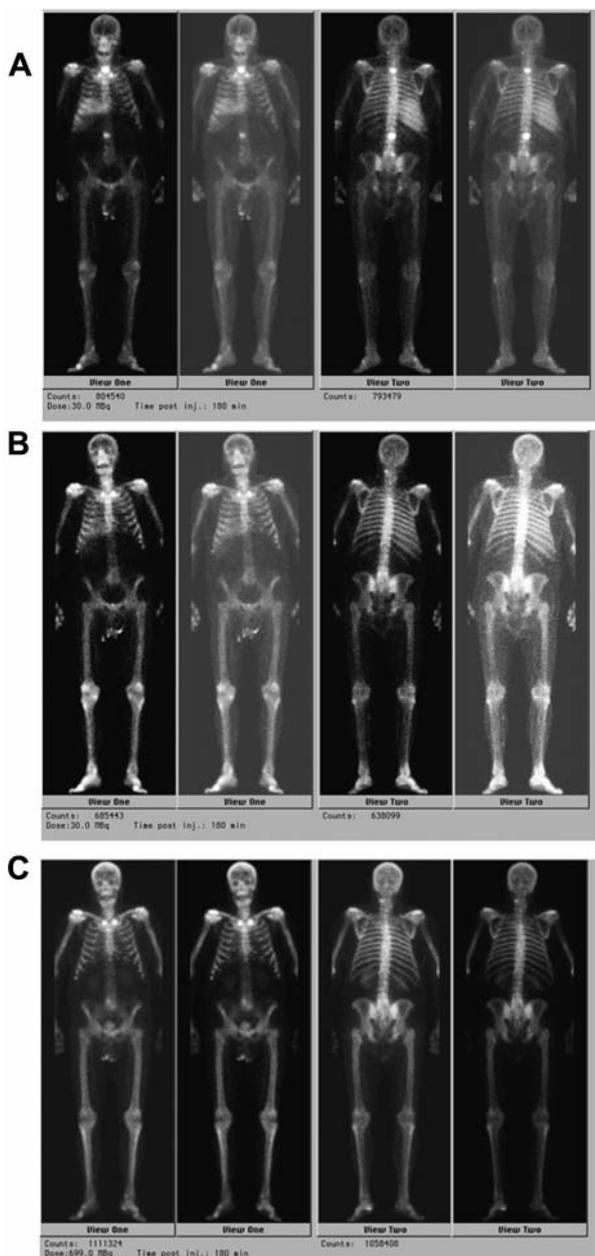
Example of lesion regression in a 74-year-old male suffering from prostate cancer. Images from A) 1st therapy (28.3.2003): two hot spots in the vertebral column verified by (MRI) reflect recurrences; B) after 5 treatments (28.4.2004), the 2 abnormal uptake sites in the vertebral column are no longer visible; C) MDP-scintigraphy (26.1.2006), still no sign of recurrences in the skeletal system.
